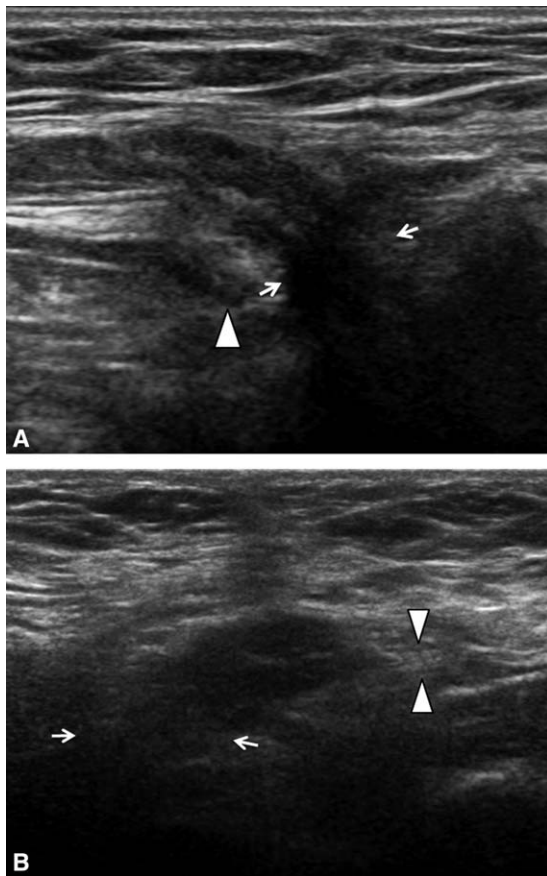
(A) Transverse sonogram of a left groin shows an indirect inguinal hernia. The neck (arrows), arising from the deep inguinal ring, lies lateral to the inferior epigastric artery (arrowhead). (B) Longitudinal sonogram from the same patient shows the neck of the indirect inguinal hernia arising from the deep inguinal ring (arrows) superior to the inguinal ligament (arrowheads).
